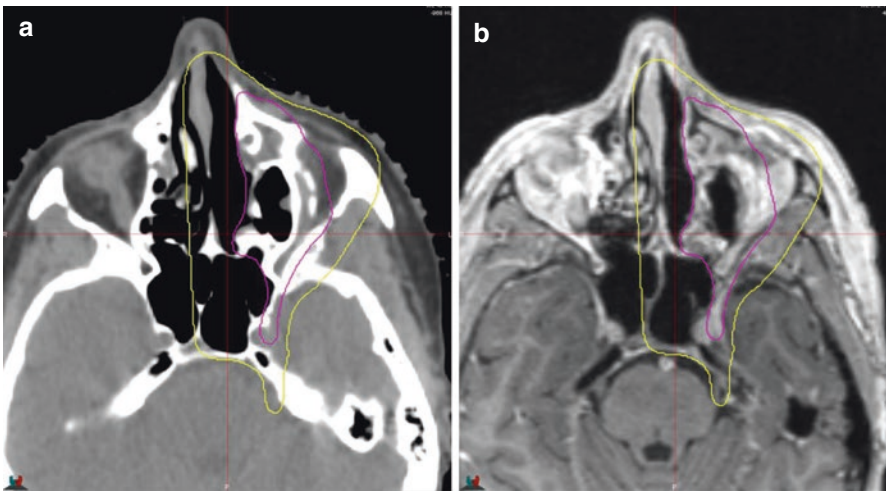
Planning CT and MRI of a left maxillary sinus squamous cell carcinoma with clinical and radiographic perineural invasion of right V2 to the cavernous sinus. The GTV is outlined in the *magenta contour*. The CTV SR is outlined in the *yellow contour* and includes the entire cavernous sinus, trigeminal nerve root as it enters the brain stem, and the retroantral space
